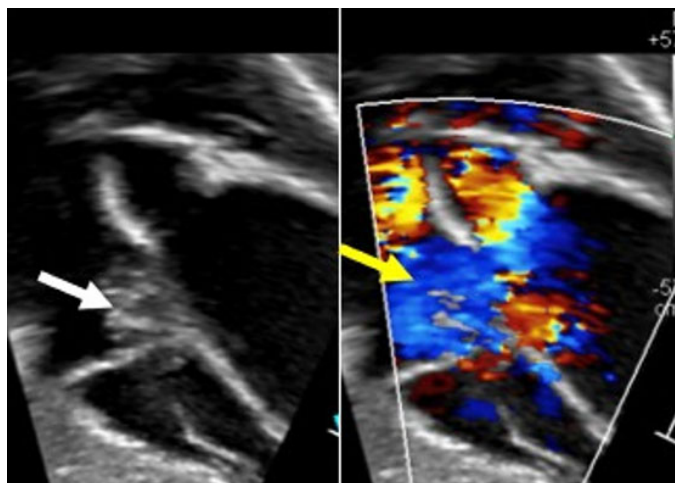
Subcostal color Doppler echocardiogram showing a nodular appearing mass (white arrow) attached to the tricuspid valve leaflet. The mass prolapses in systole into the right atrium resulting in moderate tricuspid regurgitation (yellow arrow).
